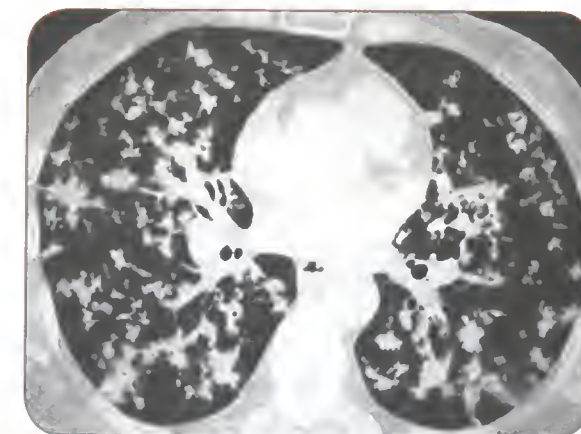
Endobronchial spread in pulmonary Koch's on CT appear as poorly defined centrilobular rosettes of nodules, 2 to 10 mm in diameter, branching centrilobular opacities, described as 'tree-in-bud'
